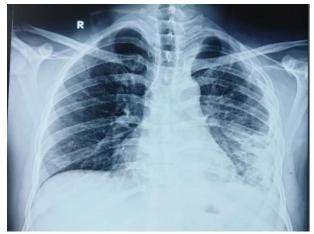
Chest radiograph at discharge.
